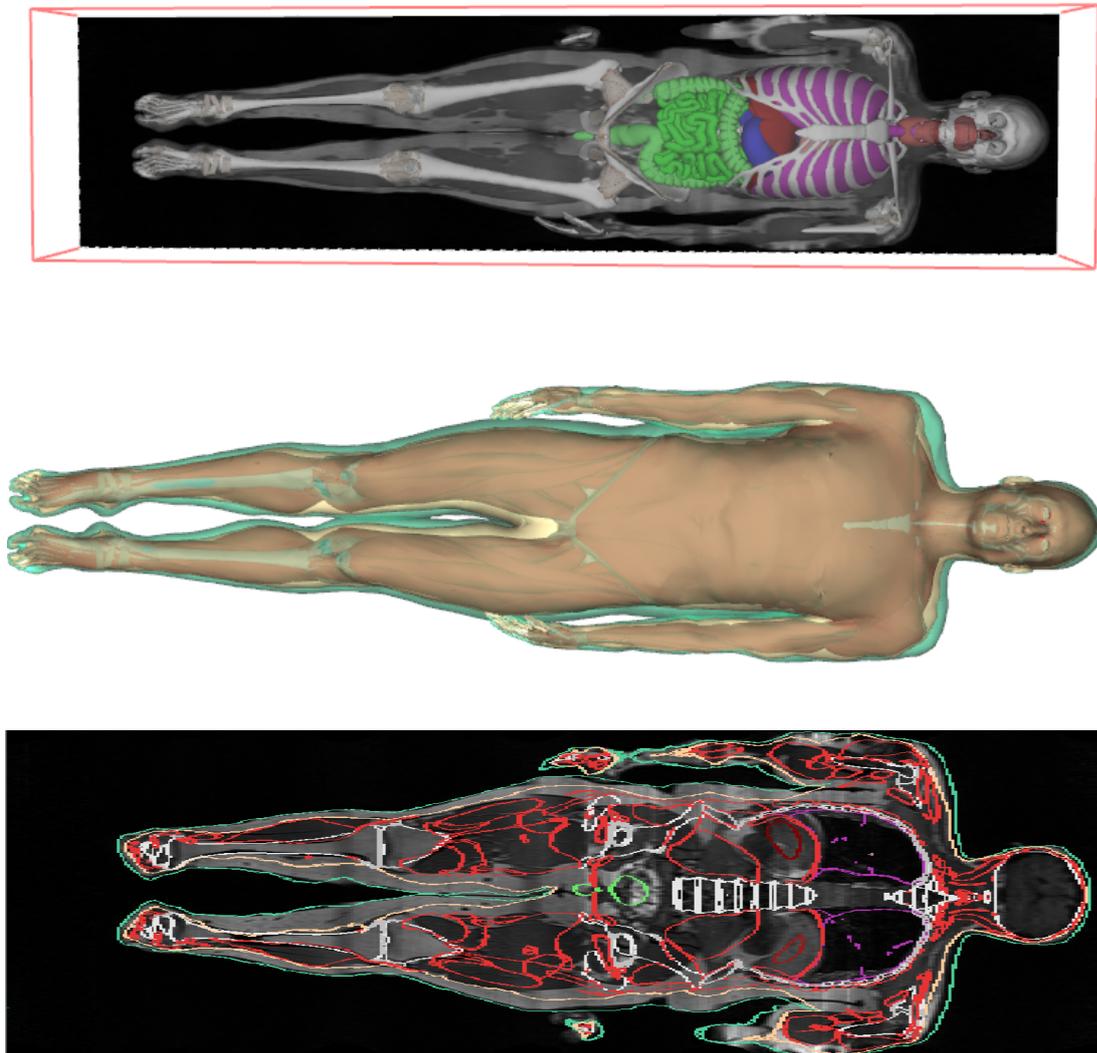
Transfer to an MRI image of a man laying on his back. Top : reconstruction of internal organs and skeleton within one slide of MRI Data. Center : reconstruction of muscular system. Bottom : comparison with the data. The green lines highlight our reconstructed surface, the beige lines correspond to the eroded volume, while the red line is muscle reconstruction, white and gray lines are bones and connectives tissues, the purple represents the lungs and the bright green represents the small intestine.*
